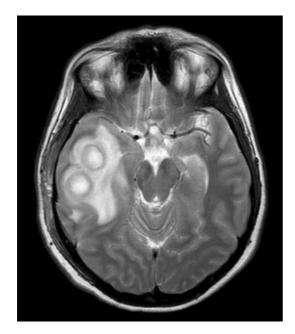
Magnetic resonance imaging of a patient with right temporal lobe brain abscess
